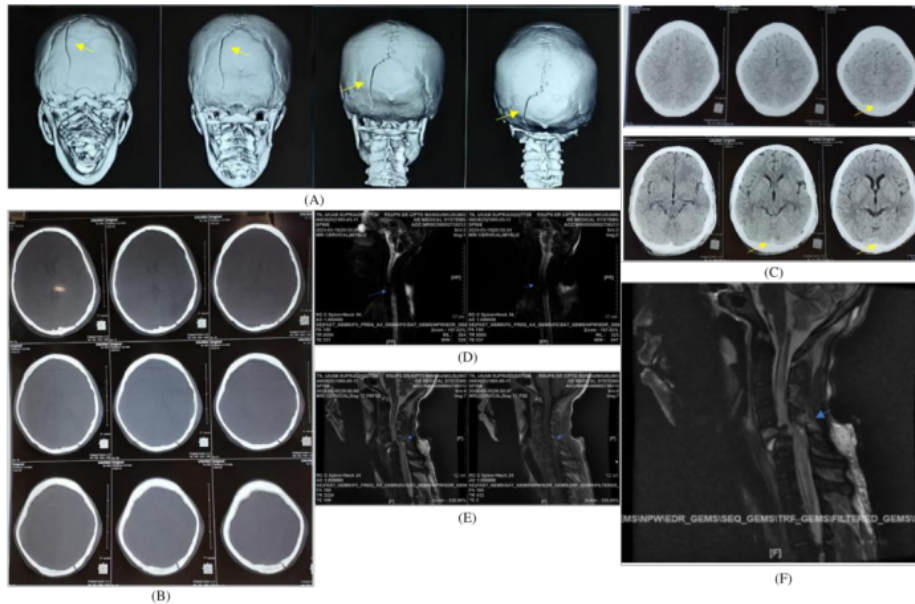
(A) Patient's Head CT Scan; (B) Head CT Scan (Bone Window); (C) Head CT scan Non-Contrast; (D) Cervical Myelography; (E) Cervical MRI Sagittal Section Sequences T1 and T2; (F) Cervical MRI Short Tau Inversion Recovery (STIR) Sequence, Cibitung Regent Public Hospital, May 4th 2023.
